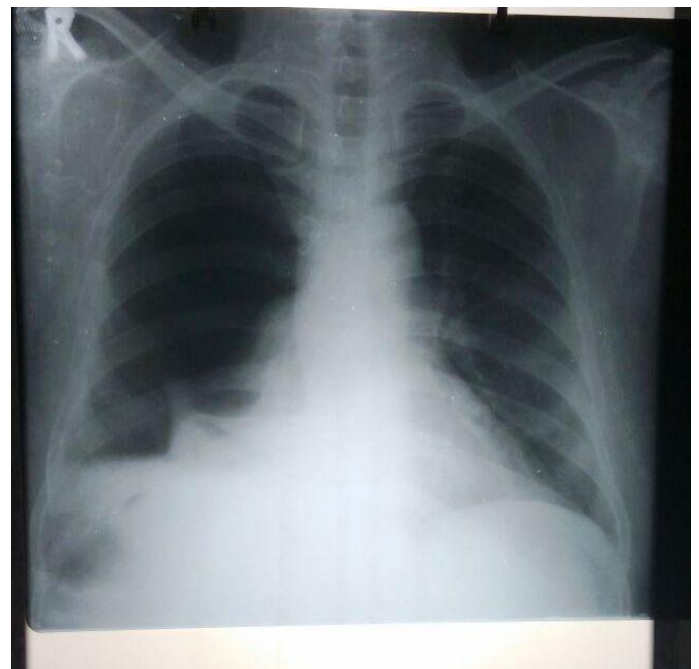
Chest Xray Showing Right Hydropneumothorax
